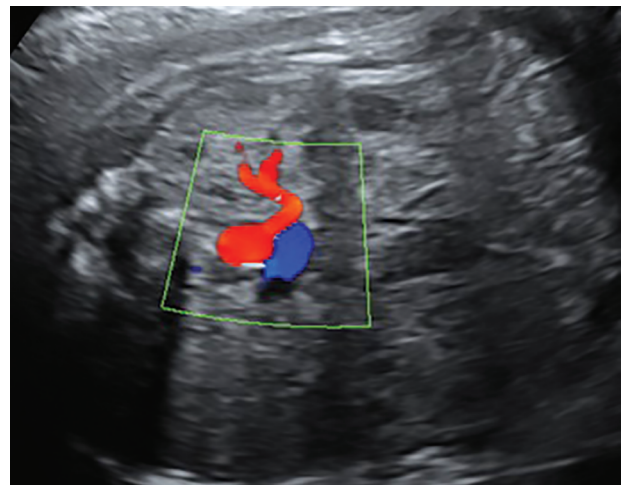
Color Doppler in transverse section of the fetal abdomen at the level of the left renal artery arising from the aorta with the large trunk (in blue) crossing the aorta
